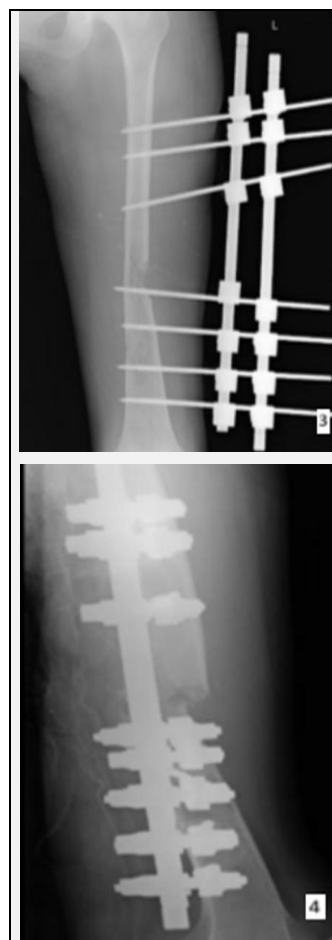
Post Op X-Ray A-P and Lateral View
